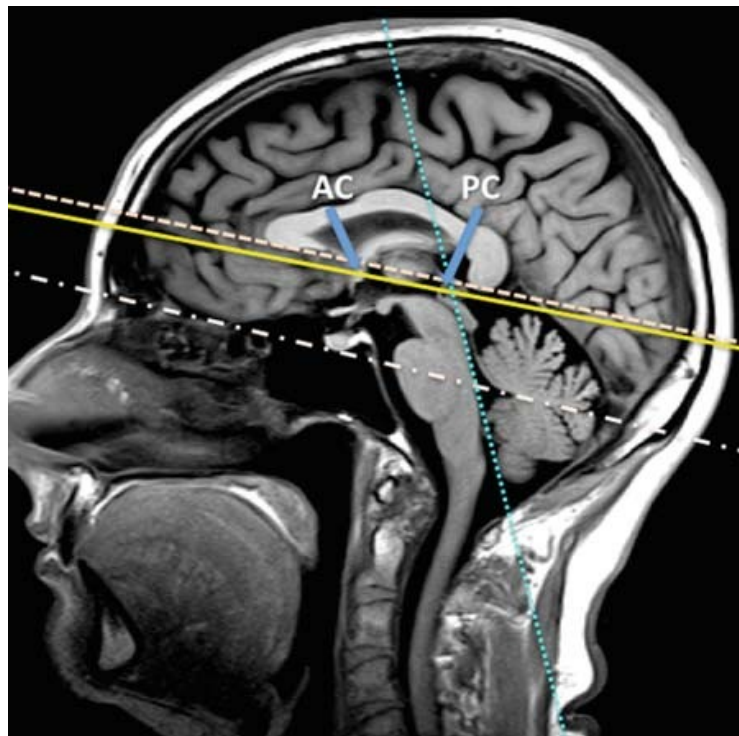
Sagittal MRI shows anatomic landmarks for positioning of axial slices. Axial slices should be positioned parallel to the bicommissural line, which links the anterior to the posterior commissure. Alternatively position slices parallel to a line linking the inferior borders of the genu and splenium of the corpus callosum
